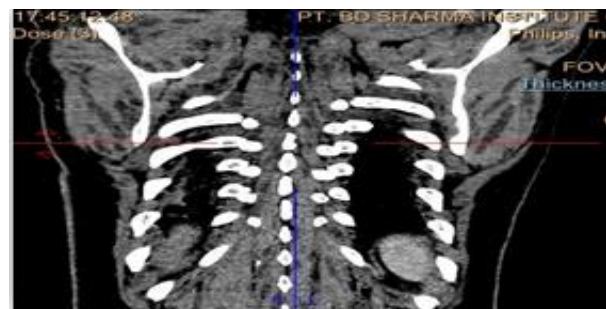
CT images showing multiple hypochoic lesions in chest wall, paravertebral and adjacent muscles, most likely multiple cysticerci.
